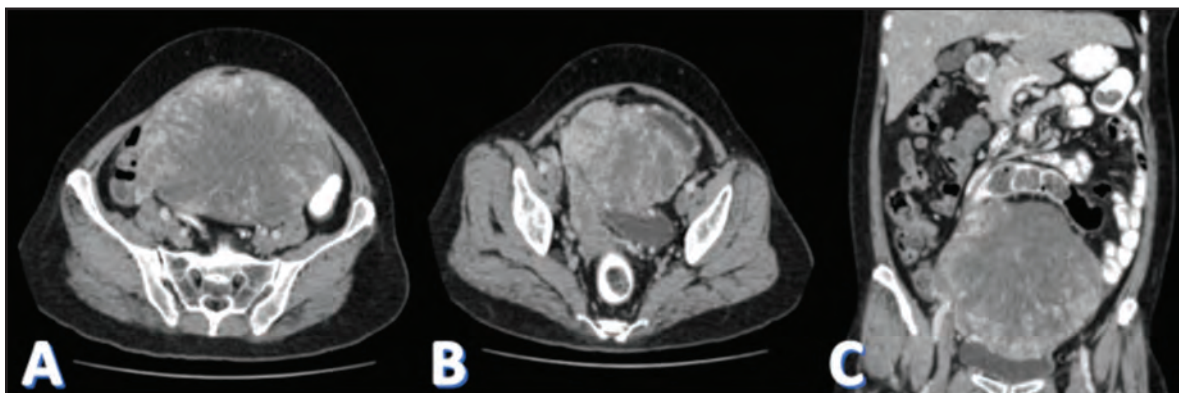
CT scan of abdomen and pelvis (A, B – transverse sections; C – coronal section) showed a solid cystic mass with no clear plane with right broad ligament and dome of urinary bladder.
